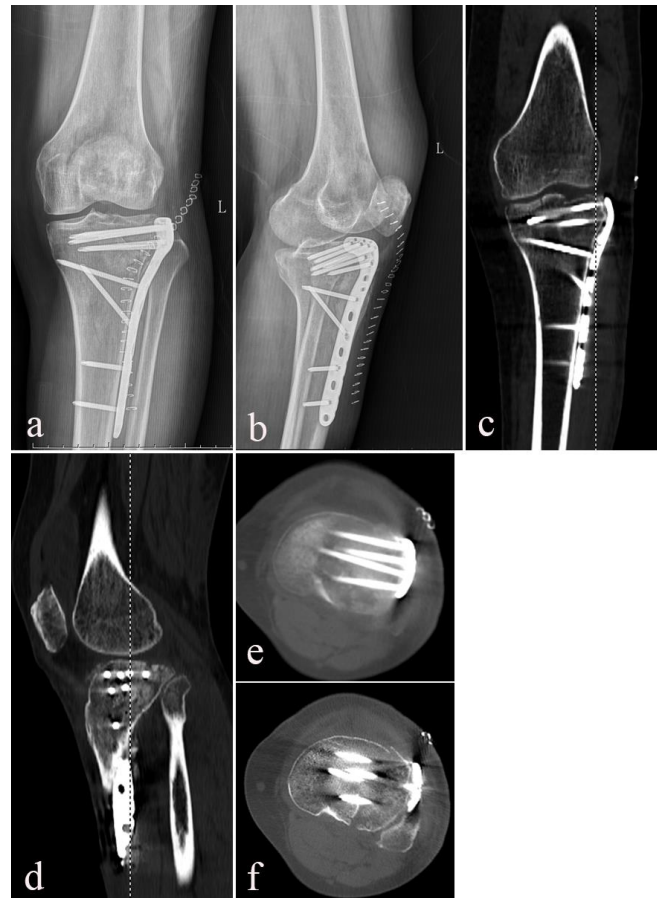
Postoperative X-rays and CT views showed collapsed articular surface was satisfactorily restored. a, b Anteroposterior and lateral views. c Coronal view. d Sagittal view. e, f Axial view.
